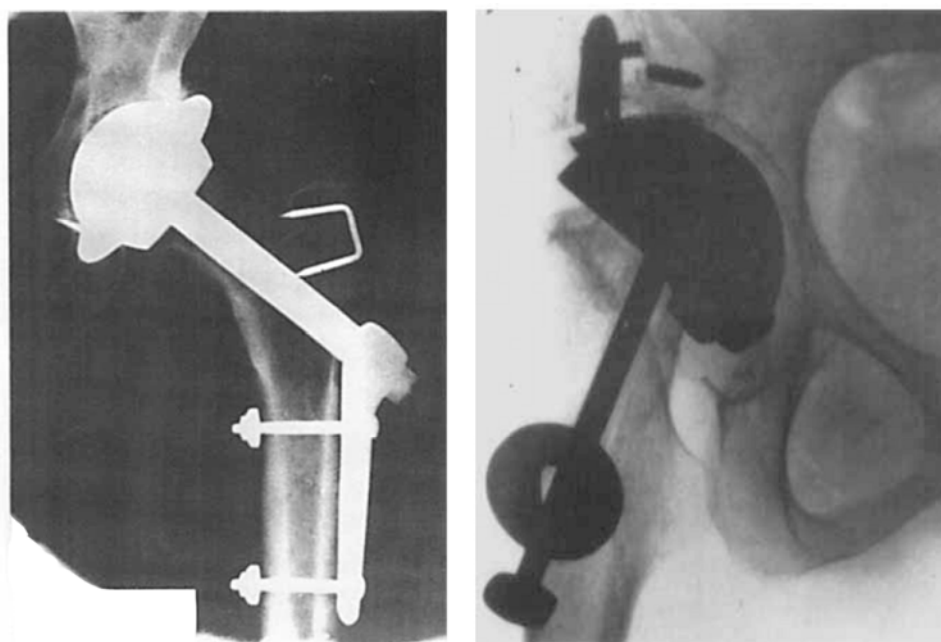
Philip Wiles's ball-and-cup arthroplasty developed in 1938. (Left) The cup was fixed to the acetabulum with two screws. Bolts passing through the femoral neck secured the femoral component. (Right) Radiograph of an implant after thirteen years. The lug and screws retaining the metal acetabulum have disintegrated, much of the neck of the femur has been absorbed, and the bolt has broken away from the head<sup>15</sup>.
